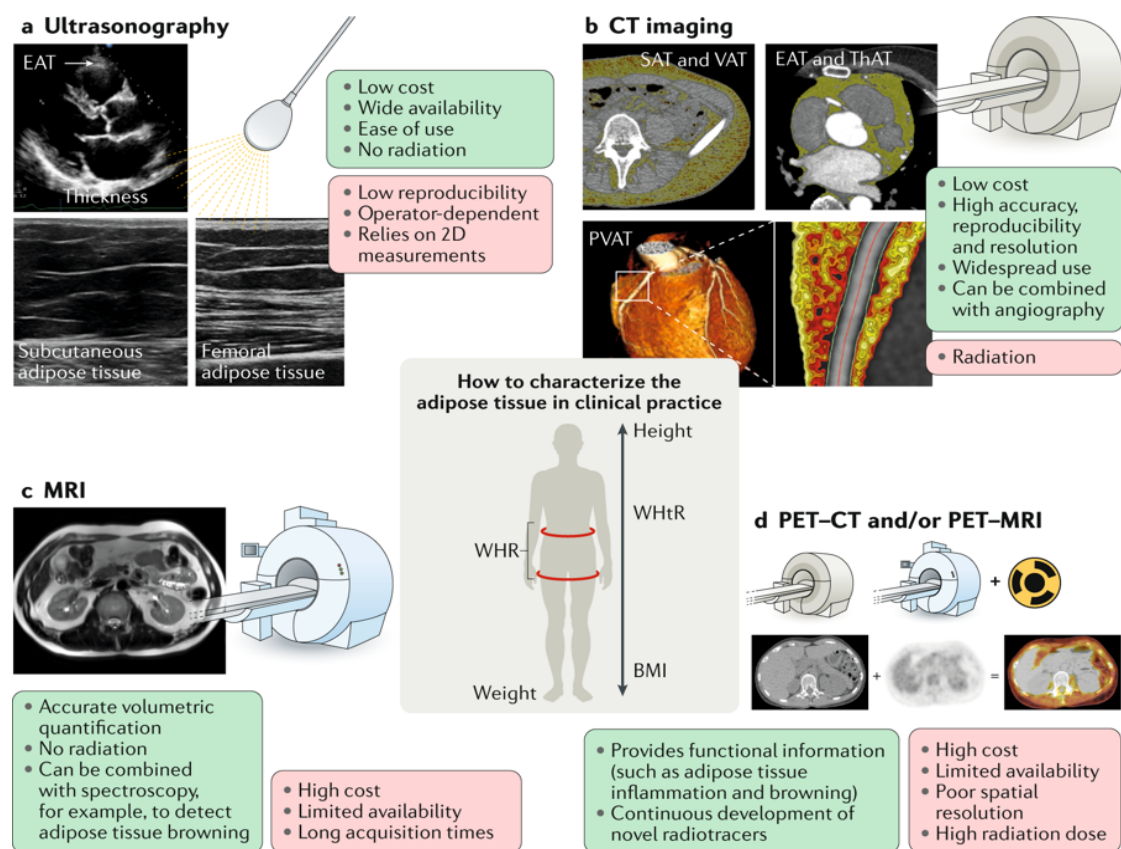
Relative advantages and disadvantages of commonly used imaging modalities to characterize the human adipose tissue. Commonly used anthropometric indices such as the body mass index (BMI) do not capture critical adipose tissue features, such as distribution, biology and overall body fat composition. Alternative anthropometric measurements, such as waist-to-hip ratio (WHR) and waist-to-height ratio (WHtR), are more appropriate obesity indices of cardiometabolic risk than BMI but still do not provide important information on adipose tissue biology and visceral distribution. Several widely used clinical imaging modalities can be employed to provide this information, with each modality having its relative advantages (green boxes) and limitations (red boxes) compared with the others. 2D: two-dimensional; CT: computed tomography; EAT: epicardial adipose tissue; ThAT: thoracic adipose tissue; MRI: magnetic resonance imaging; PET: positron-emission tomography; PVAT: perivascular adipose tissue. SAT: subcutaneous adipose tissue; VAT: visceral adipose tissue. Reproduced with permission from Oikonomou EK & Antoniadou C. *Nat Rev Cardiol*, 2019. 16(2):83-99.
